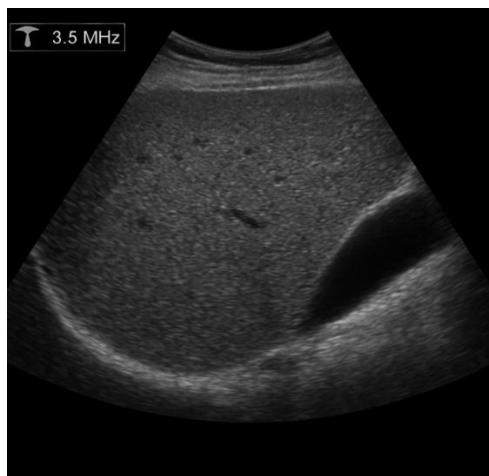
Ultrasound image of the liver using a 3.5 MHz convex probe. This grayscale ultrasound reveals a coarse echotexture of the liver parenchyma, suggestive of fatty infiltration. The diaphragm appears as a bright echogenic line at the bottom, and the gallbladder is visualized as a dark anechoic structure on the right.
